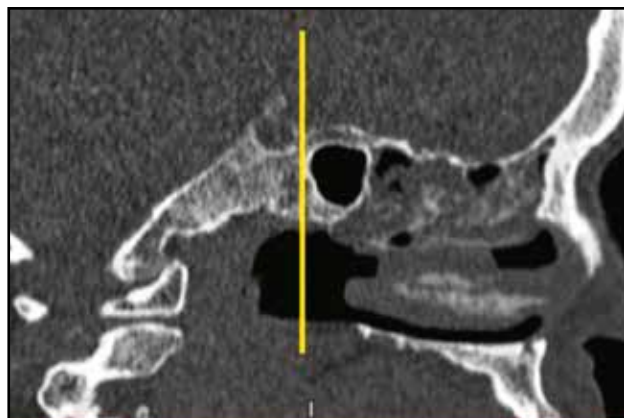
Conchal type pneumatization of the sphenoid sinus (cranio-facial CT scan, sagittal slice).
